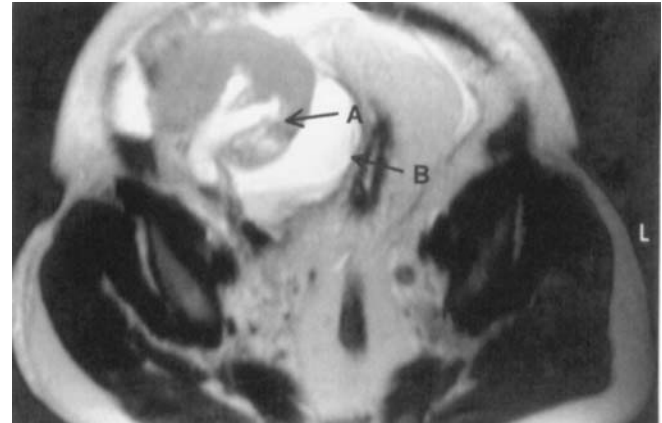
T2-weighted MRI sequence depicts the water component by its high signal intensity with the infarcted lower pole (*arrow A*) and the perirenal collection (*arrow B*)
